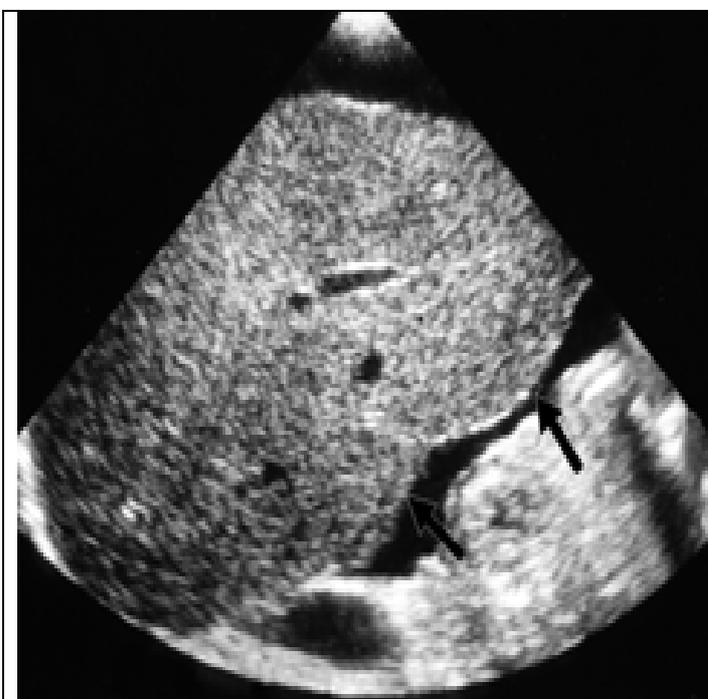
Ultrasound examination. The irregularity of the liver contour (arrows) is clearly visible because of the presence of a considerable amount of ascites. Cirrhosis of liver.
